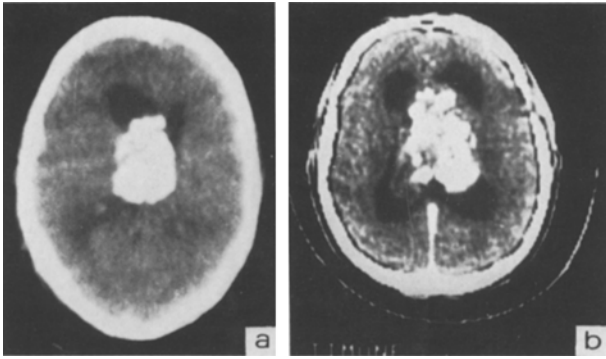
CT scans of central neurocytoma developing in the third ventricle. a Case 1. b Case 2
